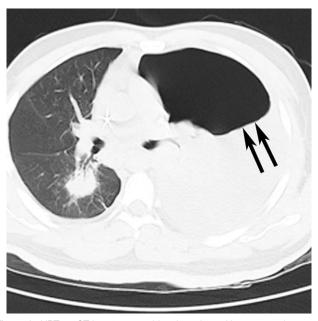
HPT on CT in a 31-year-old male patient with acute myelogenous leukemia, and with a conservative treatment duration of 90 days. HPT-gas-fluid level in left pleural cavity (black arrow), and the left lung presented atelectatic. With an infectious lesion in the lower right lobe. CT=computed tomography, HPT=hydropneumothorax.
